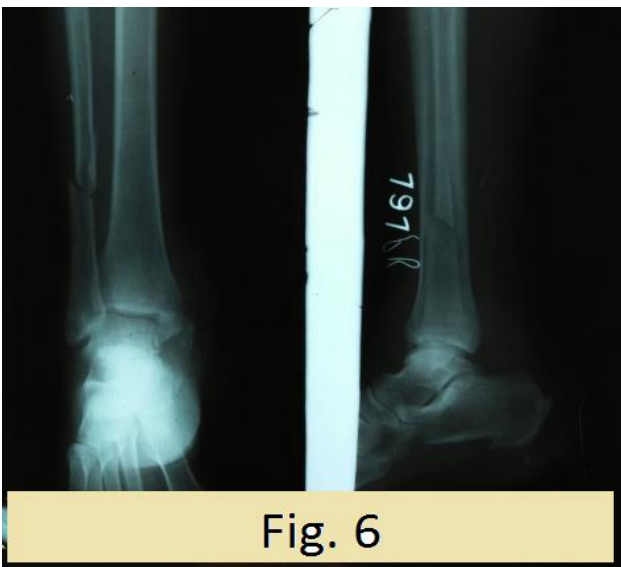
Radiograph taken in anteroposterior and lateral views: after immediate post reduction of ankle joint.
